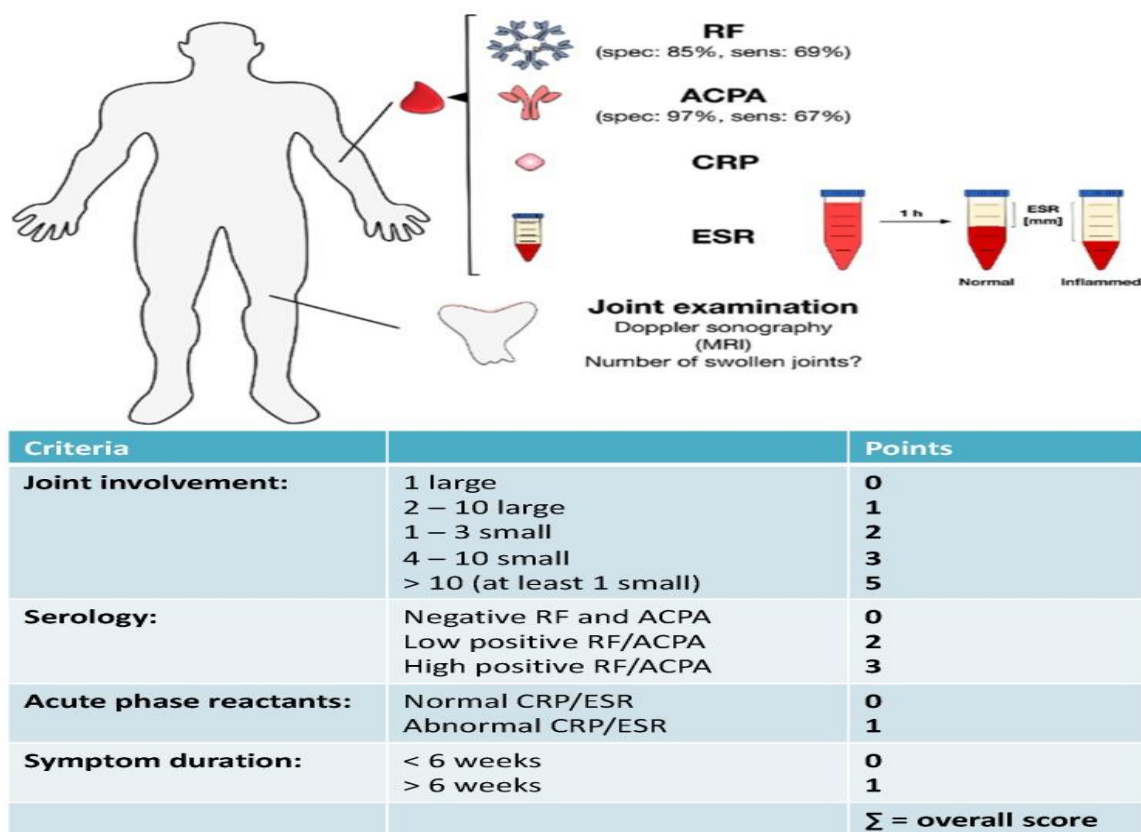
Clinical parameters commonly used in the finding of RA and their quantification using the 2010 ACR-EULAR (American College of Rheumatology-European League against Rheumatism) classification criteria. Clinical diagnosis (left) of RA depends on joint examination (chiefly via sonography, but also by MRI) and the serological purpose of RA-specific autoantibodies (Rheumatoid factor (RF) and ACPAs) and recognition of elevated levels of C-reactive protein (CRP) and an increased erythrocyte sedimentation rate (ESR). The 2010 ACR-EULAR RA classification criteria (right). Scoring parameters are the number
